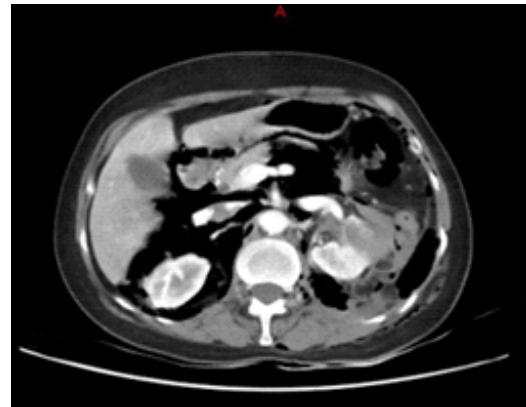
Pneumo-retroperitoneum and pneumomediastinum -CT images
